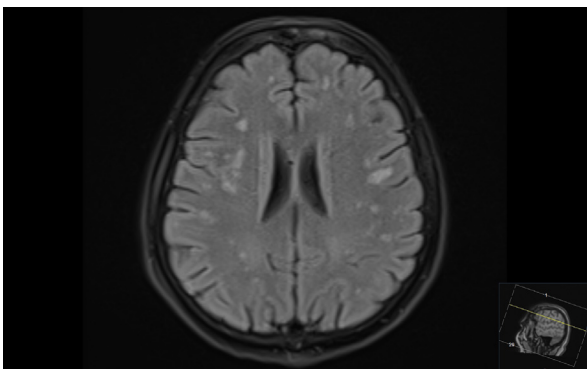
Axial FLAIR weighted MRI of a SLE patient. The hyperintense signal on the left parietal lobe shows the juxtacortical involvement of SLE.
